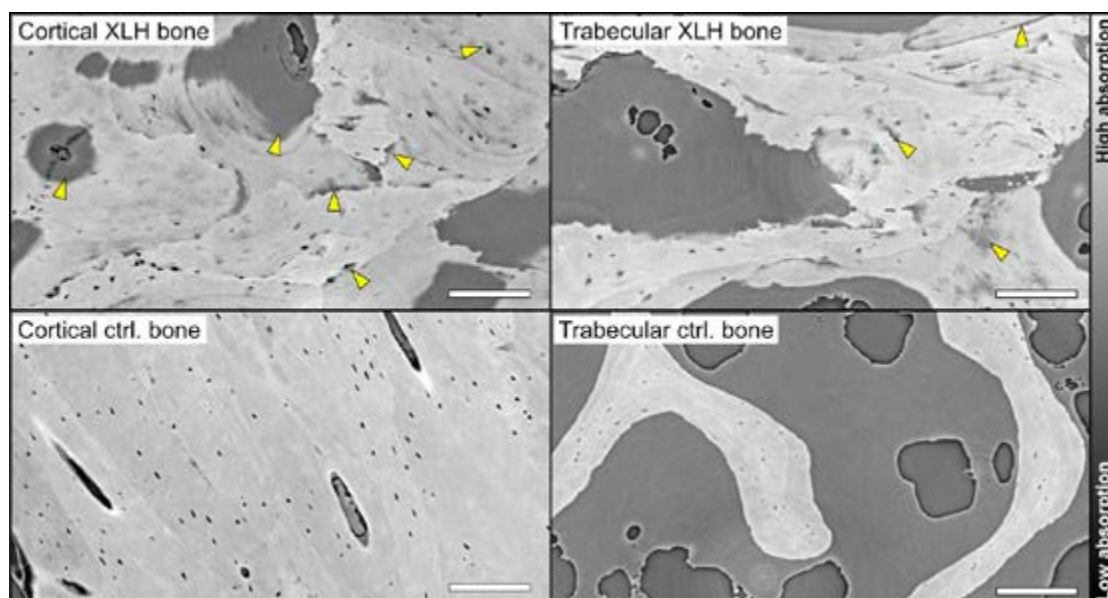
Tomographic slices from the synchrotron X-ray CT dataset showing the microstructure of a bone severely affected by XLH and a healthy control (ctrl.) bone. The mineralisation pattern in XLH bone is observed to be heterogeneous and irregular in comparison with healthy bone. Examples of non-mineralised lesions associated with Haversian canals, osteocyte lacunae, and cement lines are indicated in the XLH bone with yellow arrowheads.
